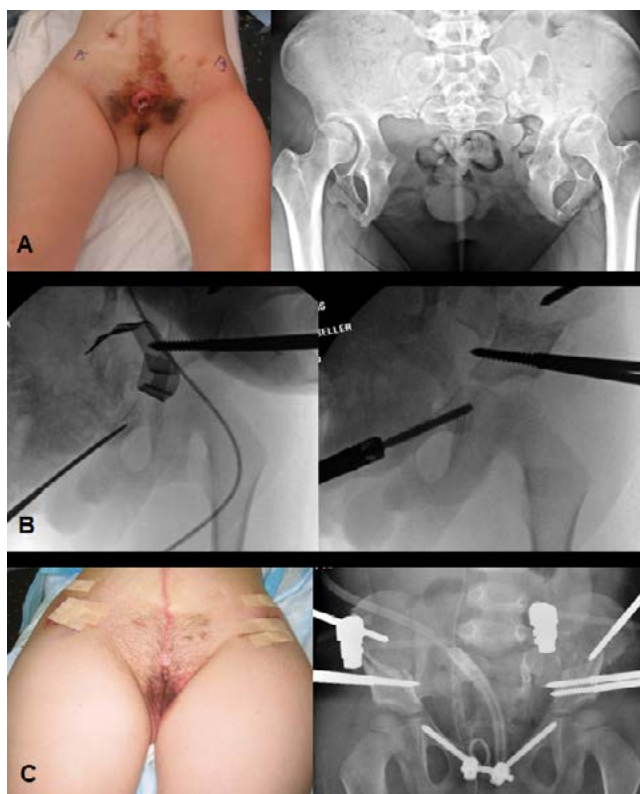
Preoperative (A), intraoperative (B), and postoperative (C) clinical and radiographic imaging of a 19-year-old female with bladder prolapse and hip dysplasia who underwent anterior pelvic reconstruction and bladder reclosure. In repeat pelvic osteotomies or when an extreme (>6cm) diastasis exists, fixation of superior pubic rami is accomplished with screws and a connecting plate or rod.
